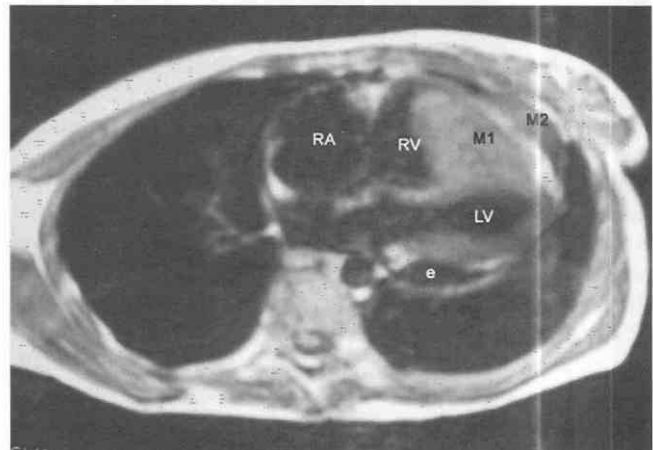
MR image obtained from a 32-year-old woman 3 years after mastectomy for adenocarcinoma of the right breast, now complaining of shortness of breath. Nearly the entire right ventricle (RV) is filled with a homogeneous intermediate-signal-intensity mass (M1). The left ventricle (LV) is extrinsically compressed by the mass. In addition, there appears to be a locus of similar material (M2) contained within the pericardial space anterior to the heart. A small posterior pericardial effusion (e) is seen as well. RA, right atrium.
